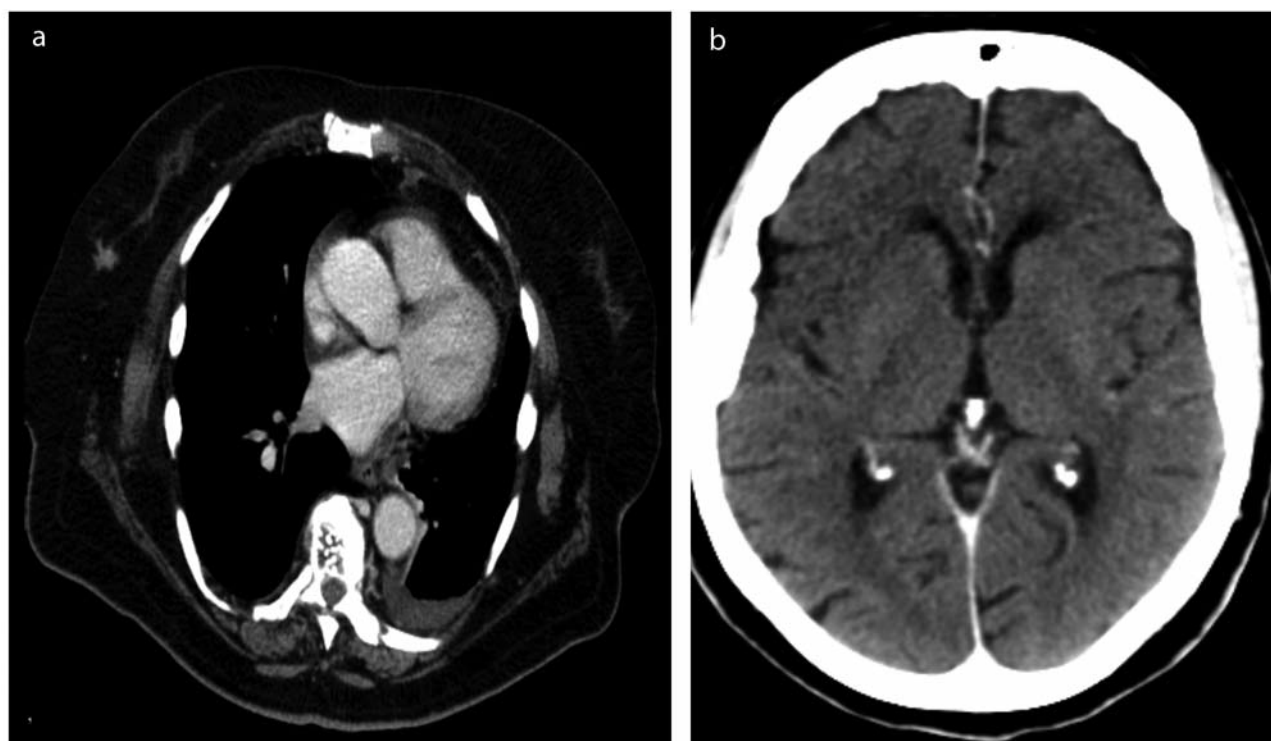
Computed tomographic scan showing stable disease of the lesion in the right breast (a) and no lesions in the cortico-subcortical region of the left frontal lobe, with no signs of edema (b).
